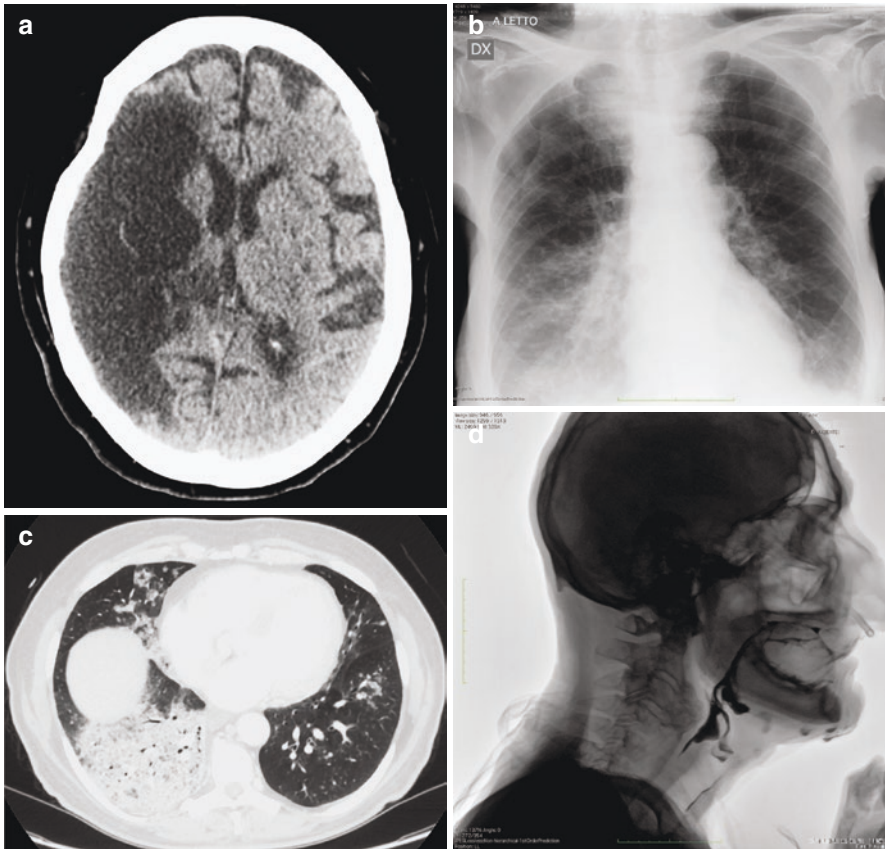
Dysphagia after stroke and aspiration pneumonia. (a) Acute right MCA territory infarct in a 63-year-old man. (b) After 8 months at emergency department, a bedside CXR shows a lower right lobe consolidation in this patient with recurrent fever, chills, and productive cough. HRCT chest axial image (c) confirms lower right lobe consolidation. (d) VFSS shows posterior oral leakage, vallecular and sinus residue, and tracheal aspiration. Dysphagia affects more than 50% of stroke survivors. Fortunately, only 15–20% of these patients remain dysphagic after 6 months
